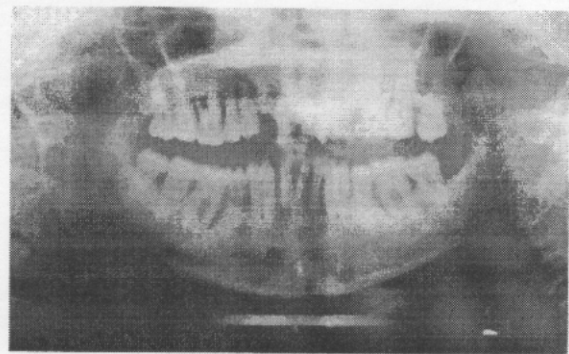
The first panoramic radiografi of patient.
